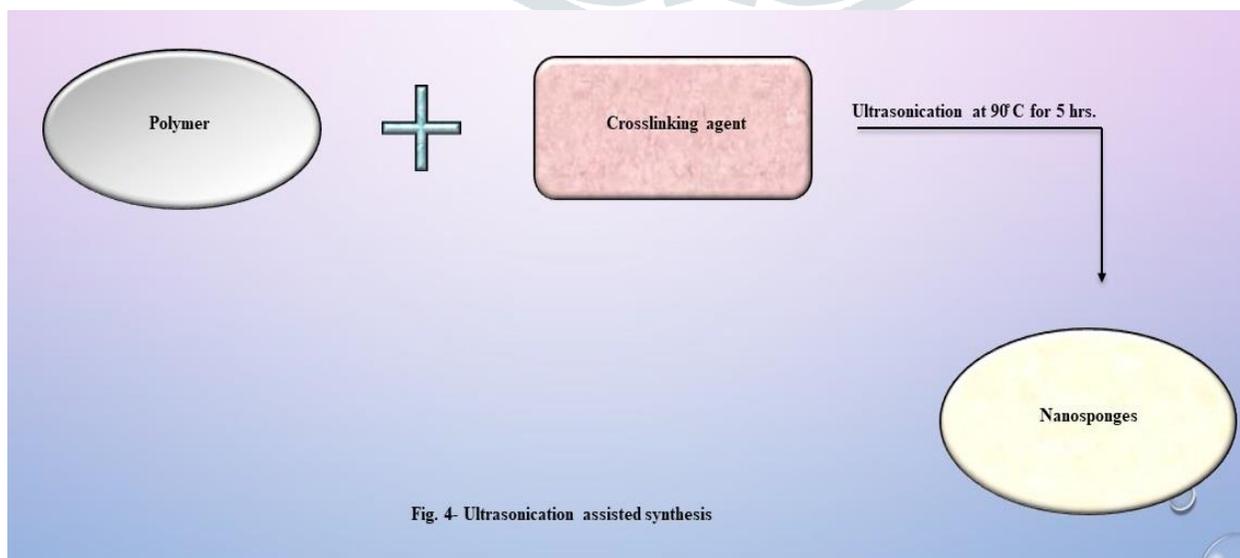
Ultrasound assisted synthesis
